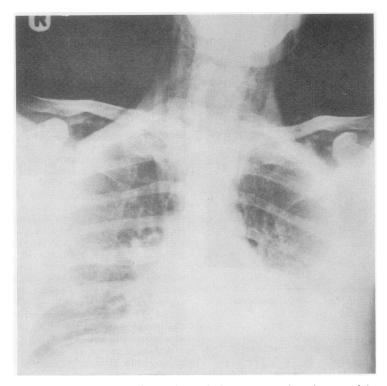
Antero-posterior chest radiograph showing surgical emphysema of the neck, a pneumoperitoneum, and fluid in the affected hemithorax following spontaneous rupture of the oesophagus.
